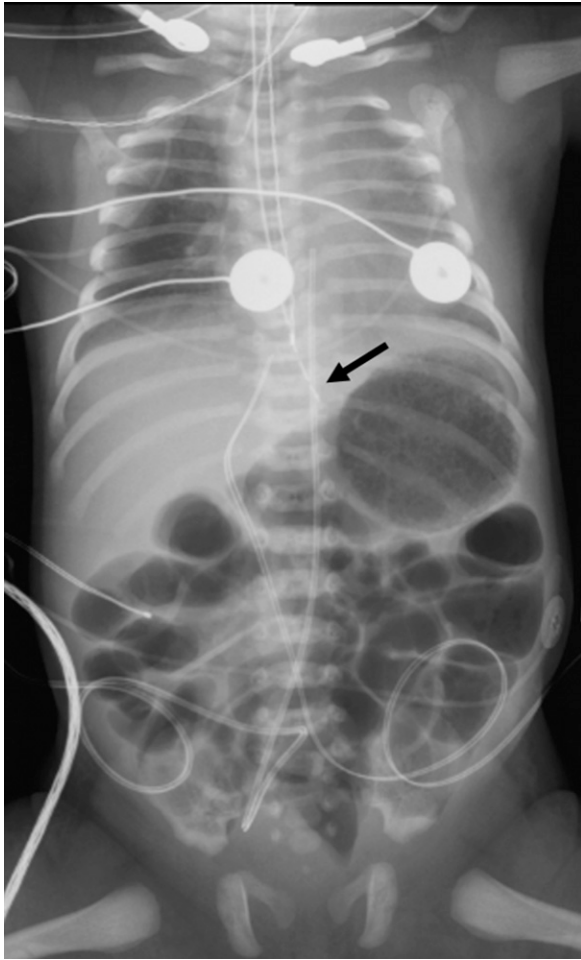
Chest and abdominal radiograph showing the tip of the Replogle tube terminating above the gastric bubble (black arrow) with diffuse gaseous distention of the bowel.
